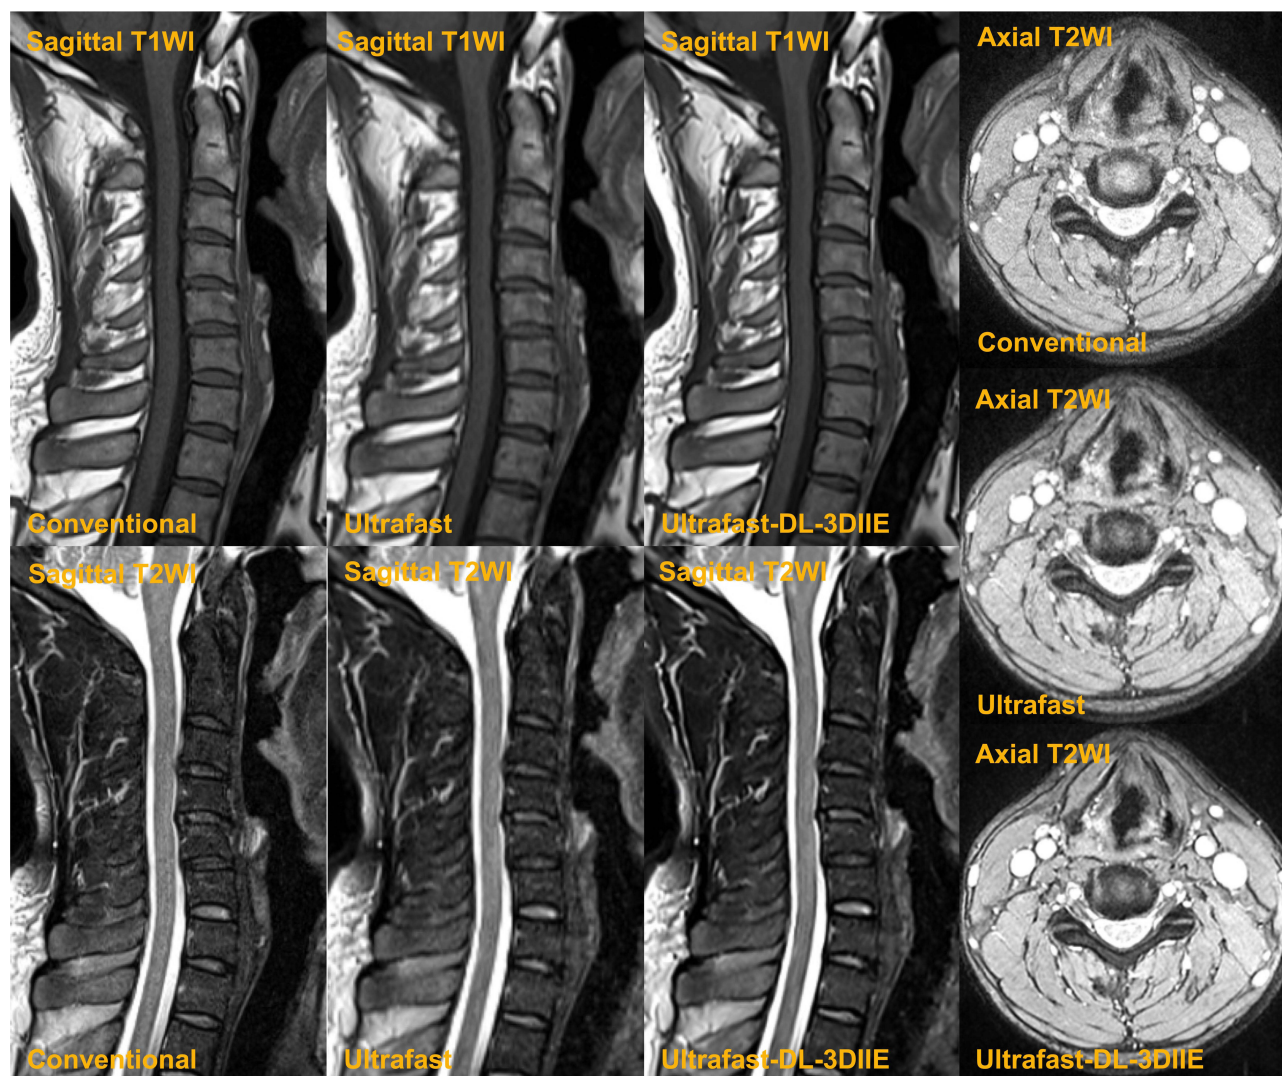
The example of sagittal T1-weighted (T1WI) and T2-weighted (T2WI), and axial T2-weighted images, obtained from conventional, ultrafast and ultrafast-DL-3DIIE protocols.
